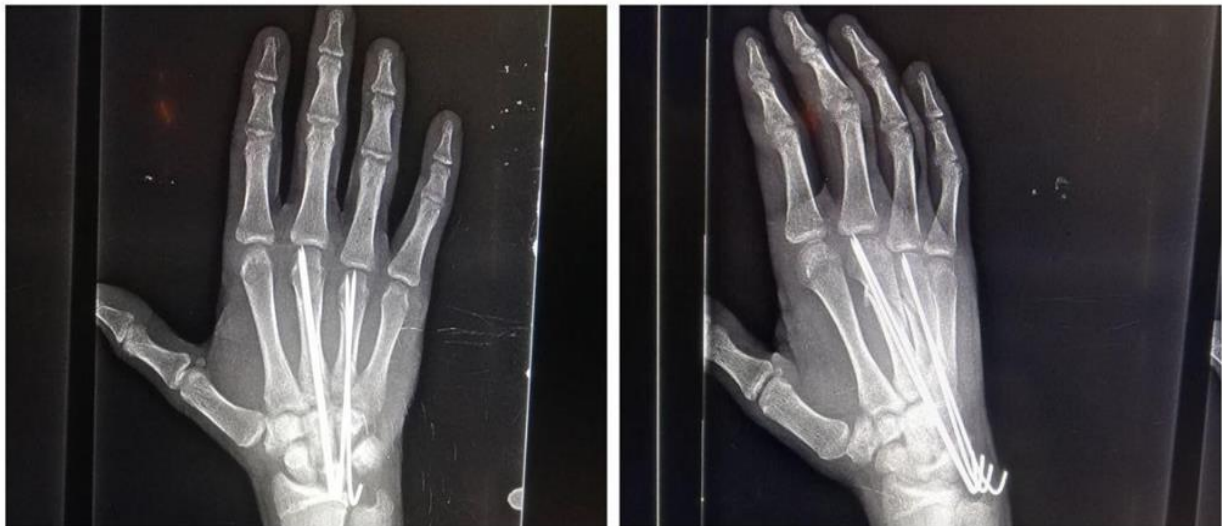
Early follow-up (4 weeks postoperative) x-rays (P.A., oblique, and lateral views) showed a stable uniting fracture.
